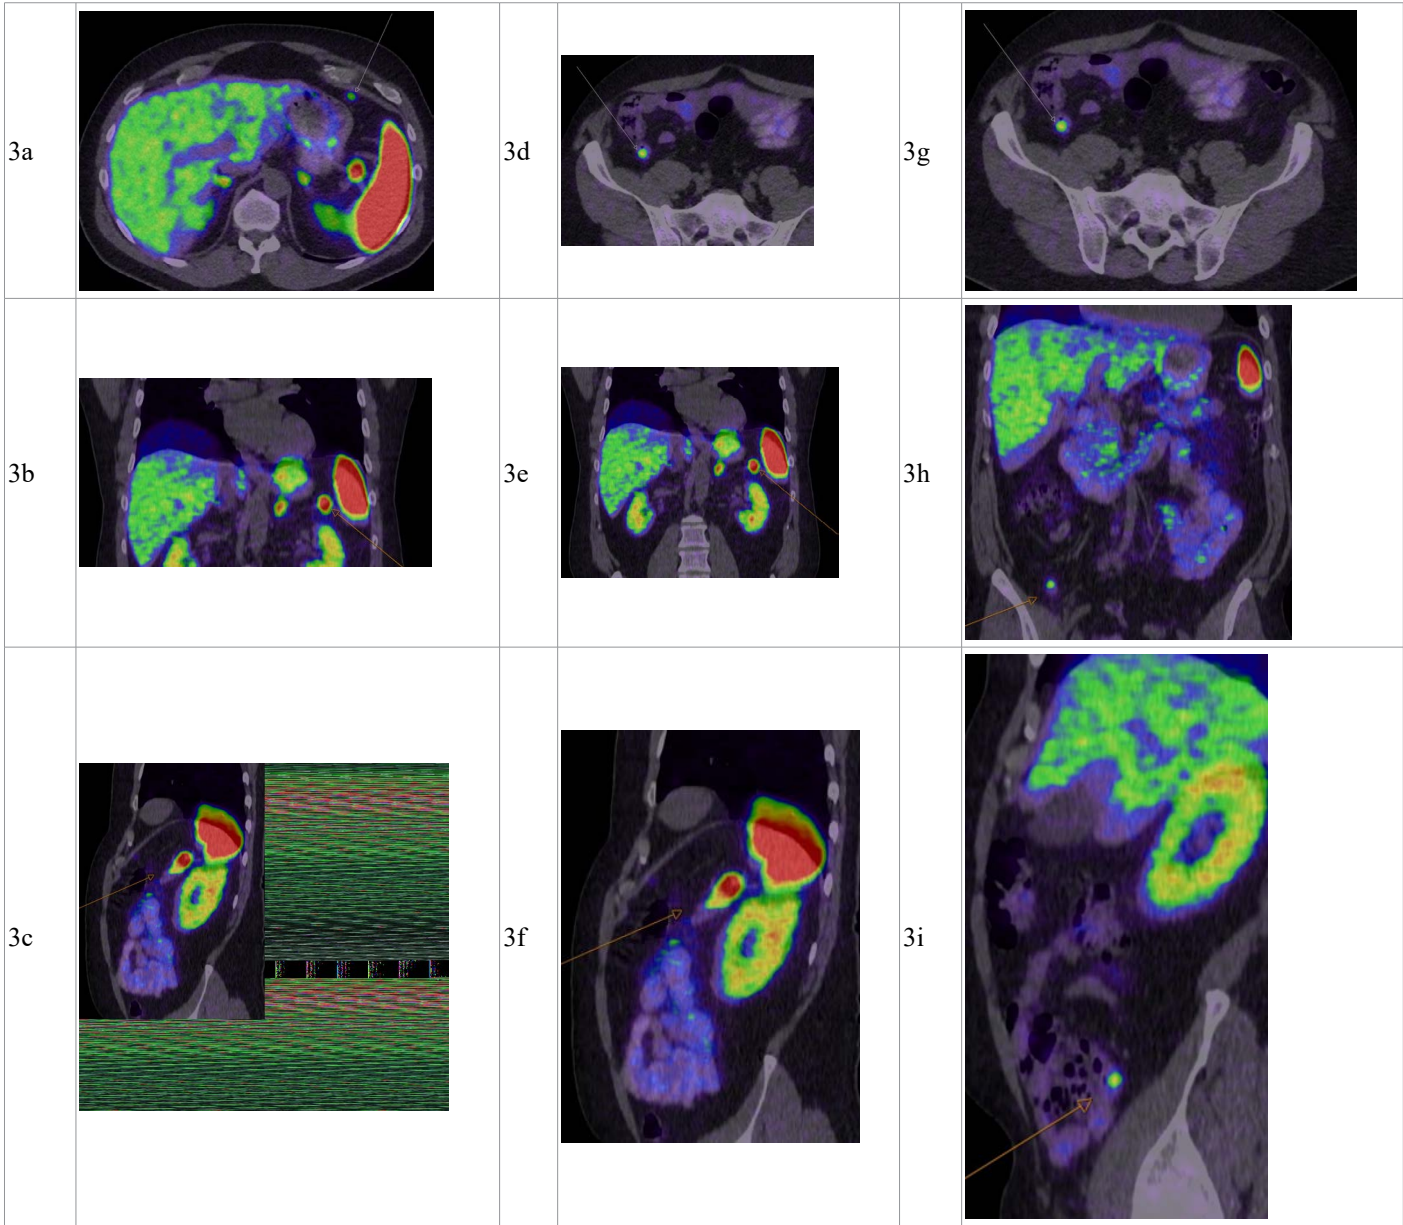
Ga-68 DOTATATE PET/CT demonstrating three somatostatin receptor-avid lesions.
